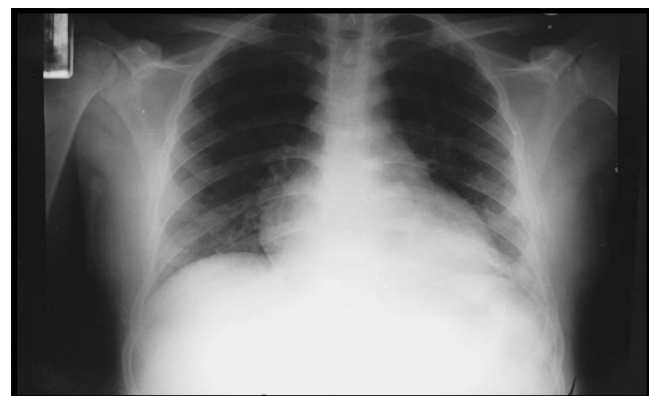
Chest radiograph 10 days after starting steroids showing significant resolution of infiltrates.
